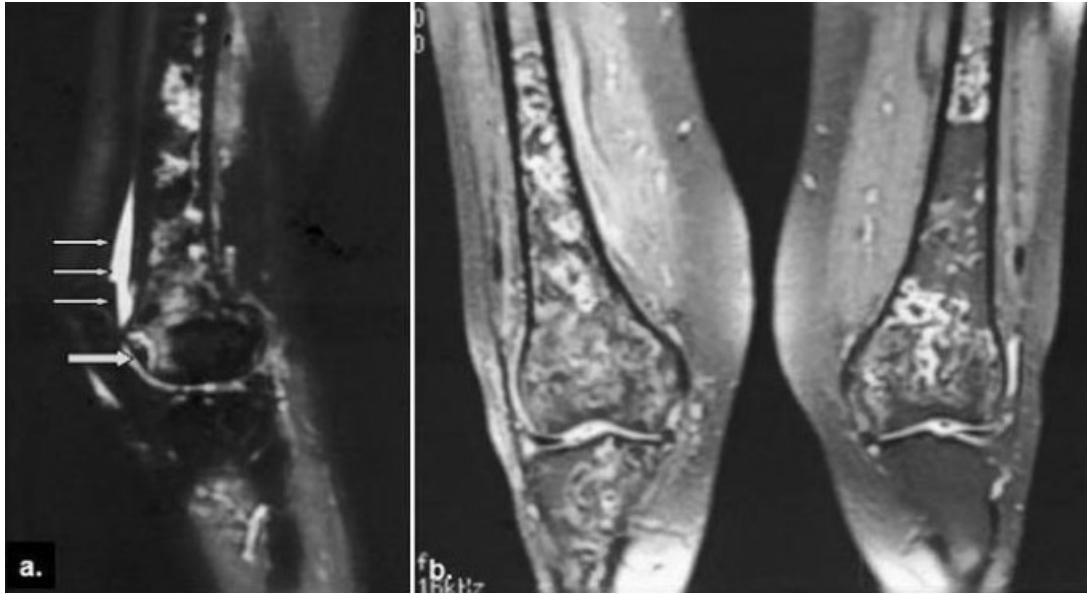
Magnetic resonance image of the patient's right knee, lateral view (a), and both knees, anteroposterior view (b). Note the subchondral defect with focal osteochondral separation in anterior right femoral condyle (thick arrow) and effusion (thin arrows).
